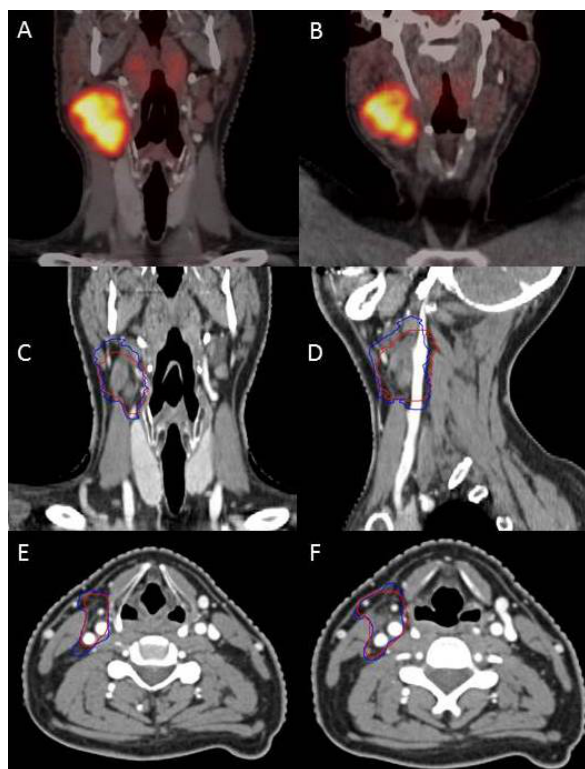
Comparison of CTV<sub>INRT</sub> and CTV<sub>diagPET</sub>. A) represents pre-chemotherapy FDG PET-CT acquired in the radiotherapy treatment-position, B) represents routine diagnostic pre-chemotherapy PET-CT with arms up, C-F) planning CT scan with CTV<sub>INRT</sub> (blue) (contoured using coregistered pre-chemotherapy radiotherapy treatment-position PET-CT) and CTV<sub>diagPET</sub> (red) (contoured using side-by-side assessment of diagnostic PET-CT) in the coronal plane (C), in the sagittal plane (D), in the axial plane at the inferior extent of the CTVs (E), in the axial plane at the superior extent of the CTVs (F).
